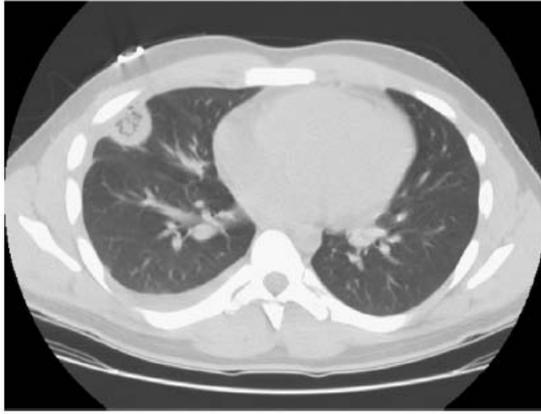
Axial CT images of the chest with contrast showing bilateral cavitary nodules, bilateral pulmonary effusions, atelectasis, and mediastinal and axillary lymphadenopathy.
